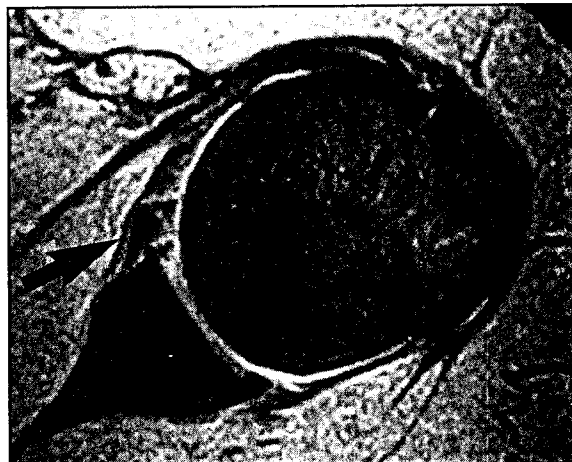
Axial magnetic resonance imaging of the shoulder demonstrating a Bankart lesion (detachment of the anterior labrum from the glenoid), indicated by the black arrow.
